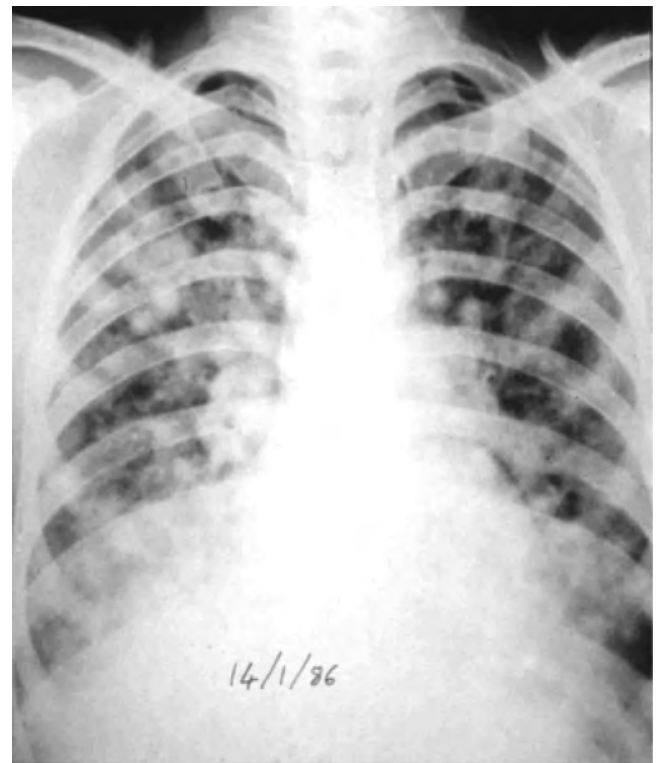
Chest X-ray showing high altitude pulmonary oedema. (From Clarke 2006, with permission from the publishers.)
